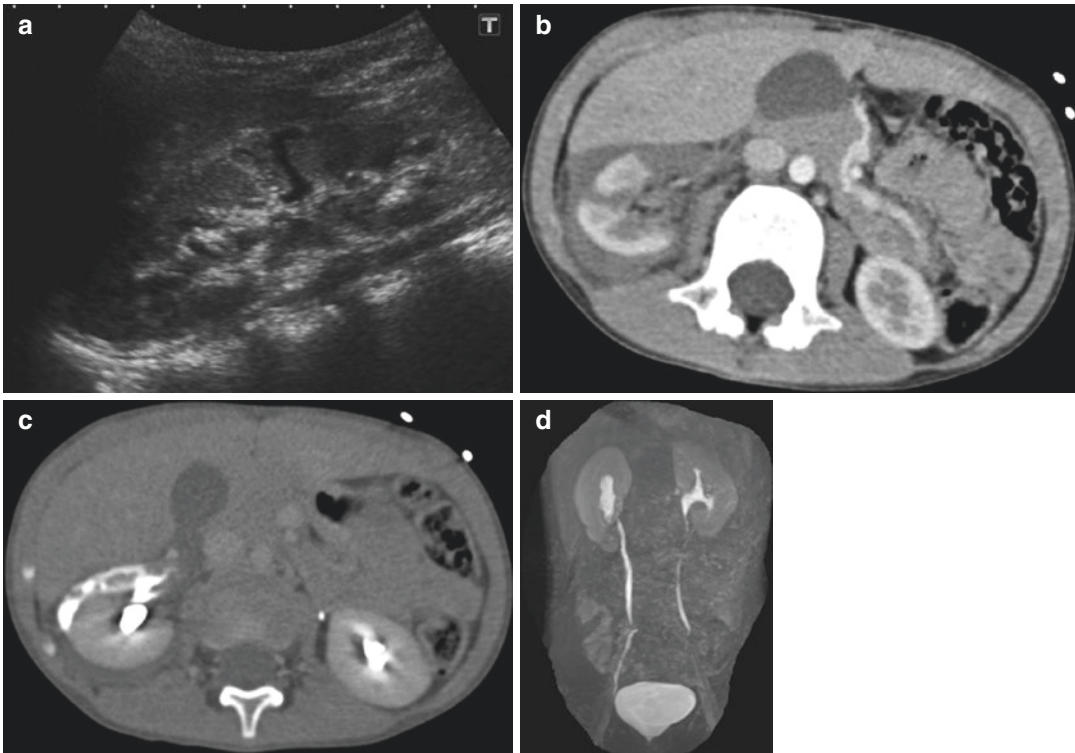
Five year old boy. (a) Initial US shows fracture of the right kidney. (b) CT with contrast (arterial phase): complex fracture of the right kidney. (c) CT with contrast (delayed phase): urinoma. (d) Functional MR urography
